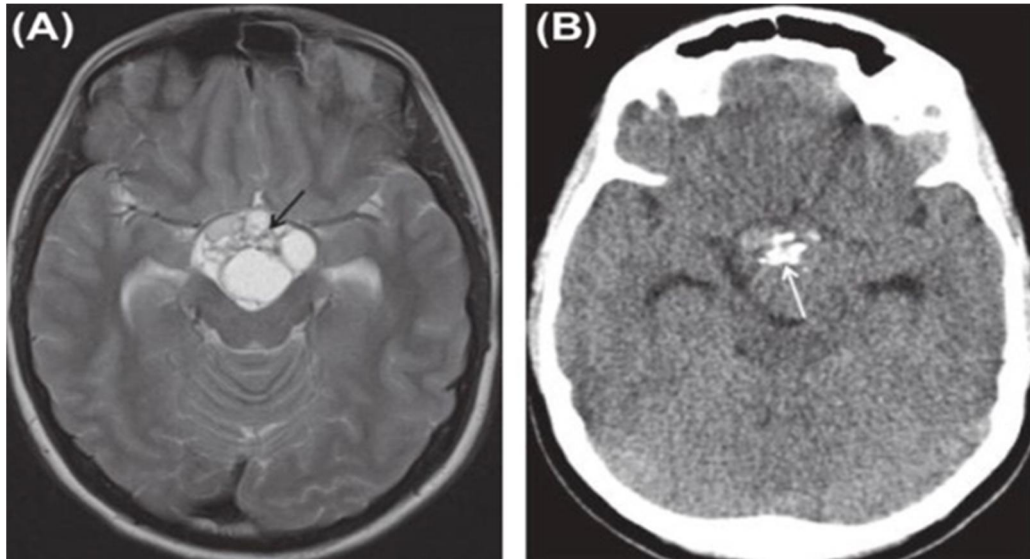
A, Axial, T2- weighted MR image shows a complex, multi cystic, suprasellar mass. The cysts have variable signal intensity, primarily reflecting different protein concentrations. Areas of hypo intensity (arrow) are related to calcification. The mass splays the cerebral peduncles. B, Axial, non-contrast CT image shows calcifications (arrow) corresponding to the areas of hypo intensity on MR imaging.
